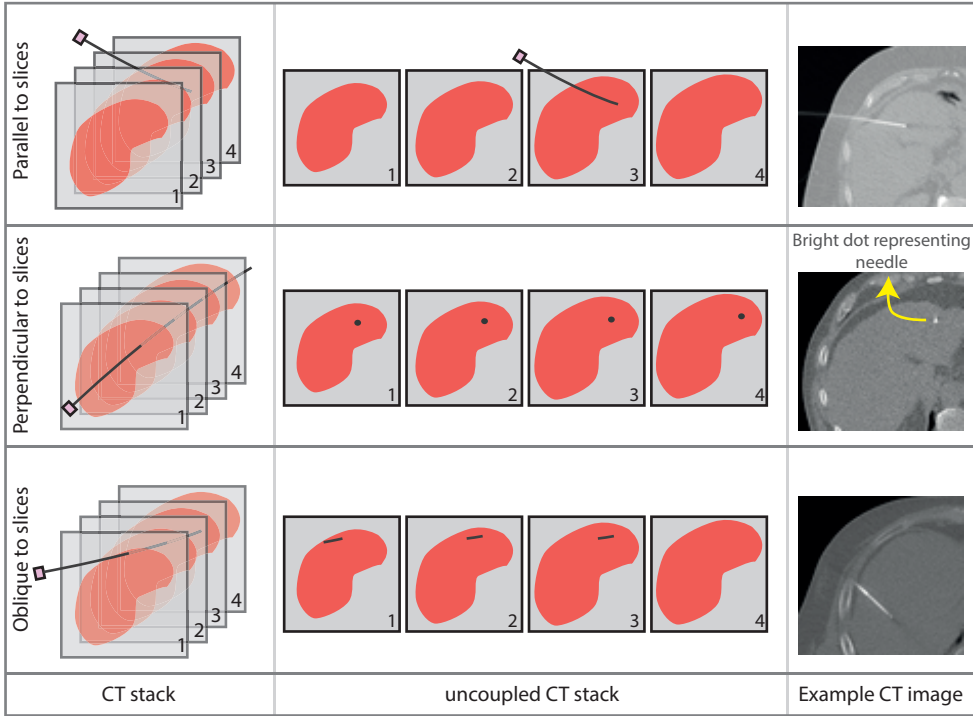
Needle orientations with respect to the axial CT slices. The needle can either be projected parallel, perpendicular, or oblique.
